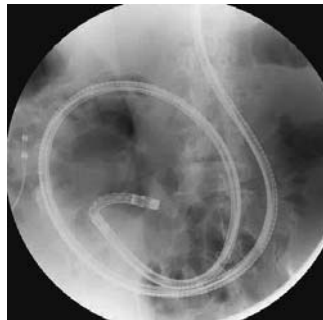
FIGURE e25-8 Radiograph of a double-balloon enteroscope in the small intestine. (Image courtesy of Dr. Ananya Das; with permission.)
